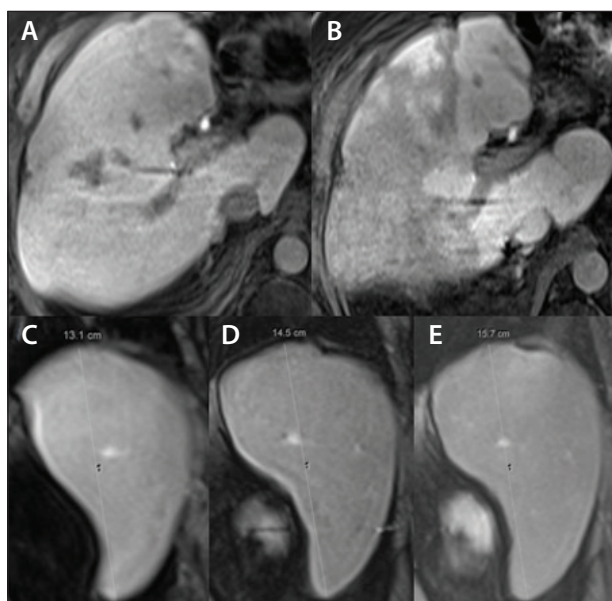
Pre- and post-Y-90 selective internal radiation therapy (SIRT) with apparent hepatic fibrosis and splenomegaly. Eovist MRI during the hepatobiliary phase before Y-90 SIRT (A) and at 4-month follow-up after Y-90 SIRT (B) demonstrating new areas of band-like signal abnormality. Serial preprocedural (C) and 1- and 4-month (D, E, respectively) postprocedural images of the spleen showing progressive splenic enlargement after Y-90 SIRT.
